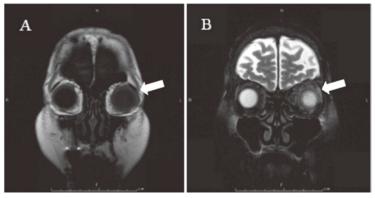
MRI of the orbit (A; T1 weighted image, B; T2 weighted image)
